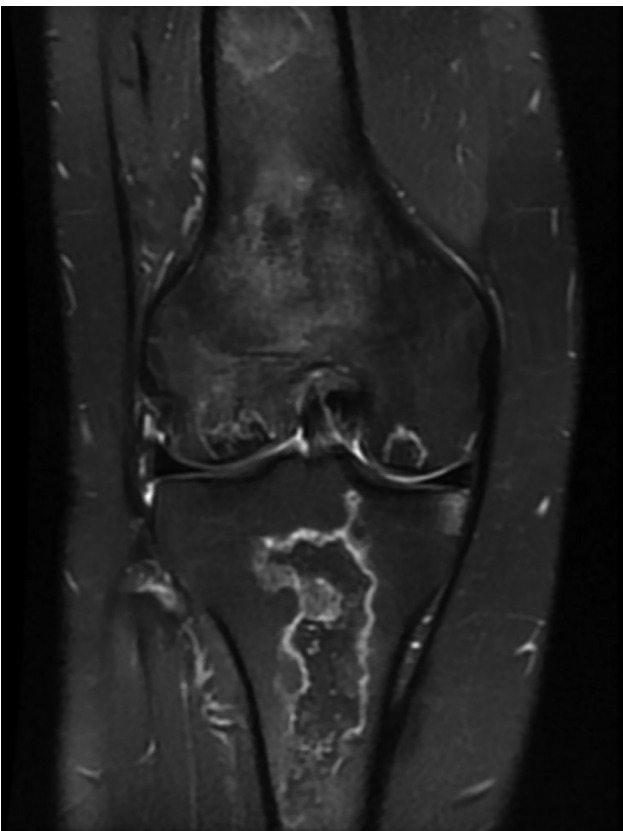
Coronal proton density fat saturated (PDFS) image of the right knee demonstrating involvement of the proximal tibia not seen on the corresponding x-ray (Fig. 1).
